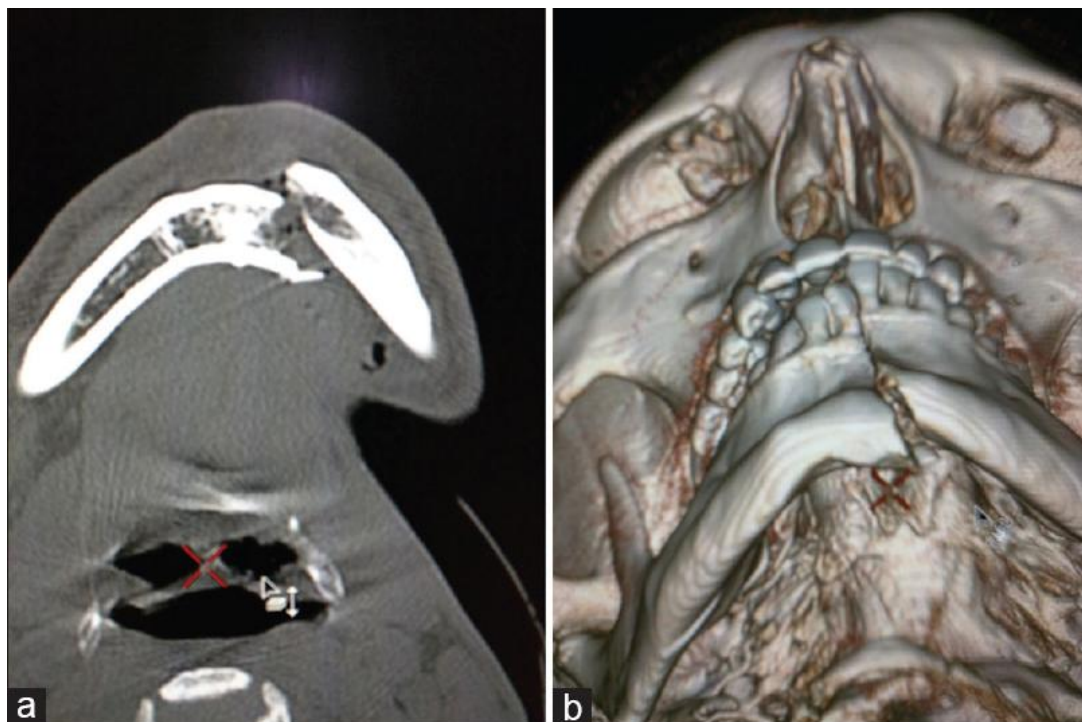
(a) Axial computed tomography images showing displaced linear fracture in the left parasymphiseal region of the mandible. (b) Three-dimensional rendered images showing better understanding fracture pattern and extension
